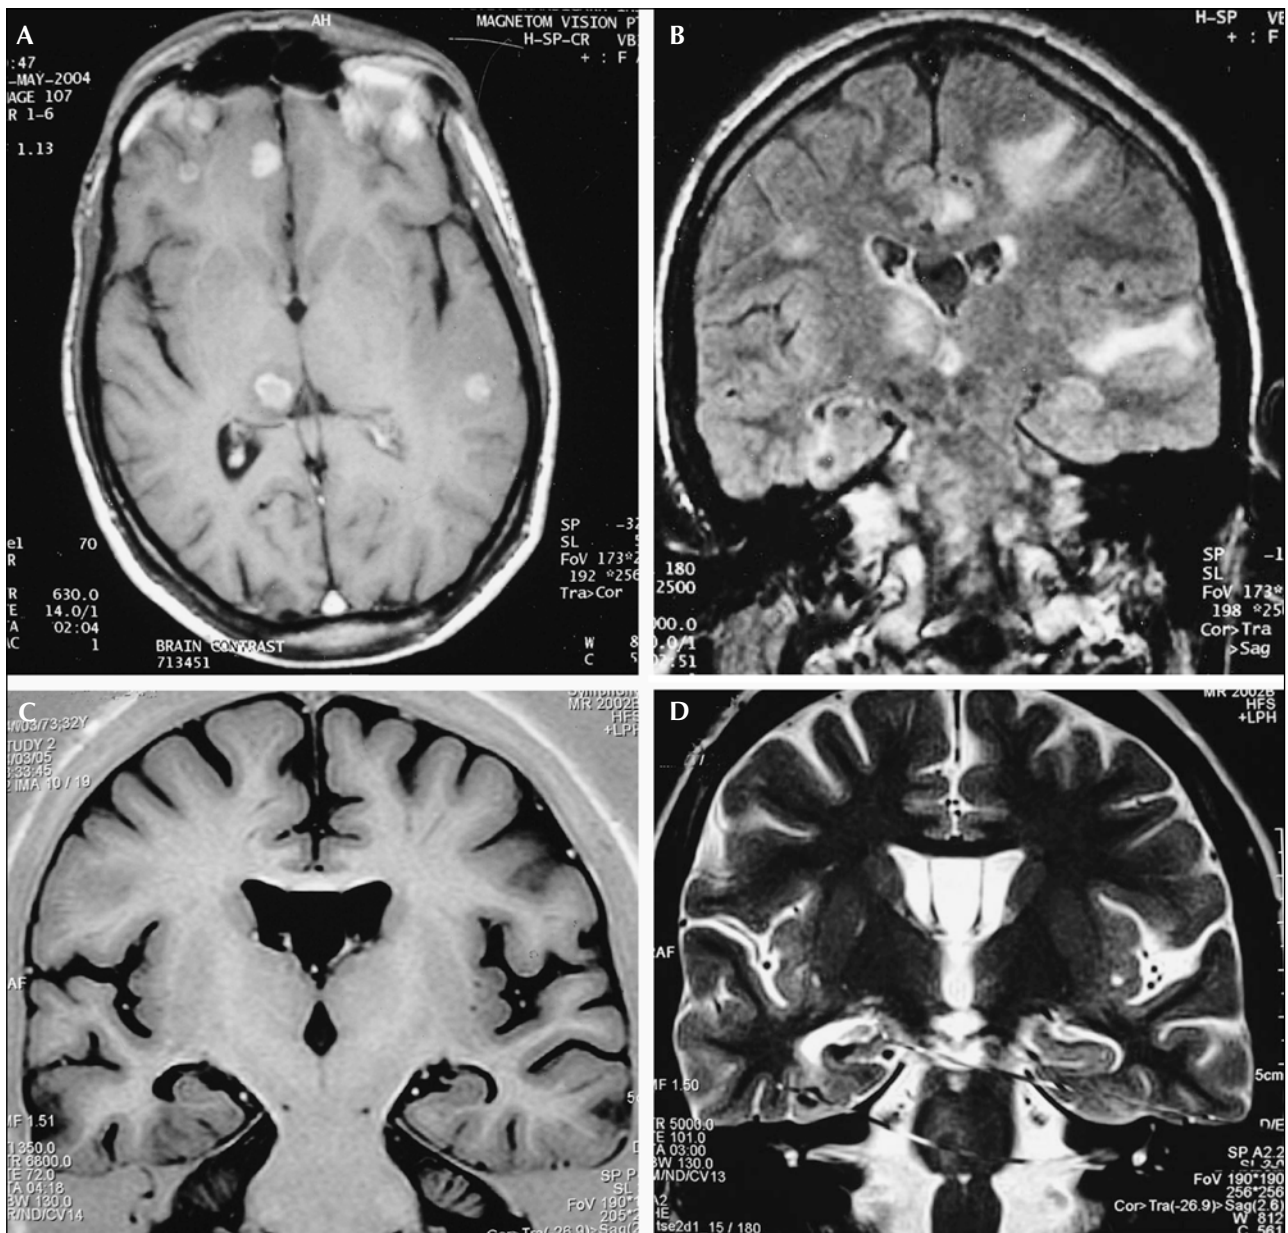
Case 3. A, B Initial images, gadolinium-enhanced T1 weighted image showing multiple enhancing granulomatous lesions (A) and FLAIR coronal image (B) emphasizing the edema around the lesions. Note the lesion in the right para-hippocampal gyrus (C, D). Follow-up T2 (C) and T1 (D) coronal oblique sections showing right hippocampal atrophy (C) and hyperintensity (D). Note the calcified lesion in the right para-hippocampal gyrus (C).
